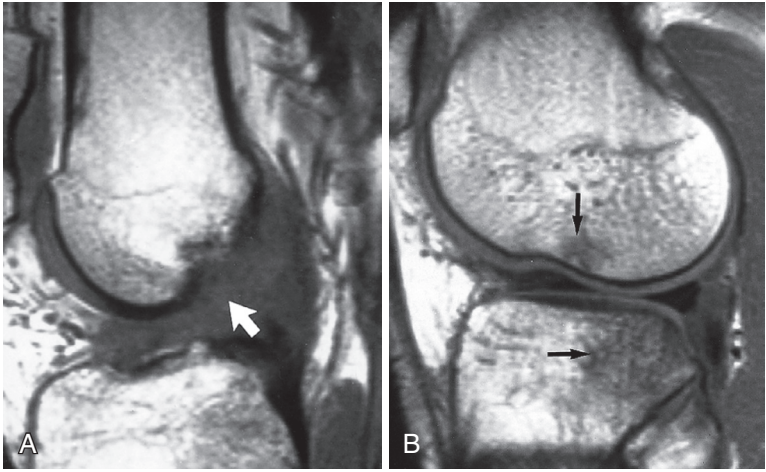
Magnetic resonance imaging (MRI) appearance of acute ACL rupture. A, Sagittal T1-weighted MRI of the knee demonstrates a mass of intermediate amorphous signal in the expected location of the anterior cruciate ligament (ACL) (*arrow*), consistent with a complete tear of the ACL. B, Further laterally, low signal in the posterior tibia and lateral femoral condyle represents typical contusions seen in association with ACL injury (*small arrows*). (From Adam A, et al. Grainger & Allison's diagnostic radiology. 5th ed. Edinburgh: Churchill Livingstone, 2008, Fig. 46-81.)
